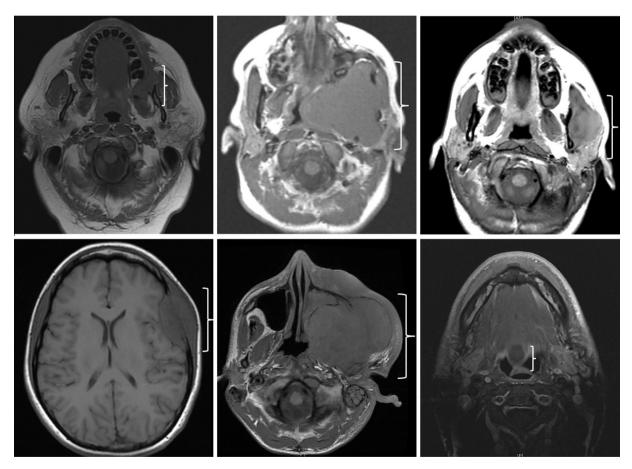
Radiographic findings of head and neck spindle cell/sclerosing rhabdomyosarcoma. MRI axial views of 6 patients showing large tumor masses causing a mass-effect, erosion and destruction of nearby bony structures.
